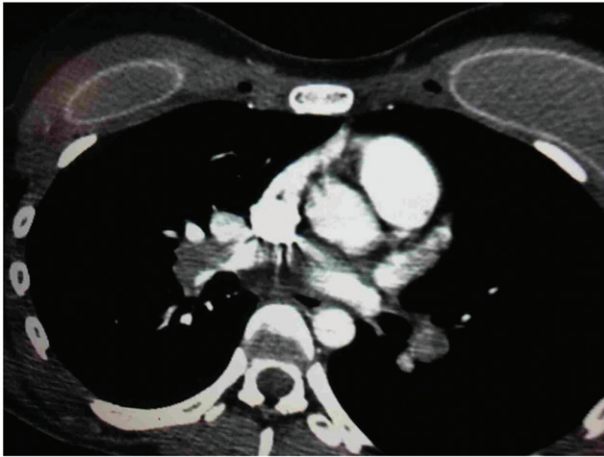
Axial angio CT image showing bilateral pulmonary embolism and the presence of breast implants.
